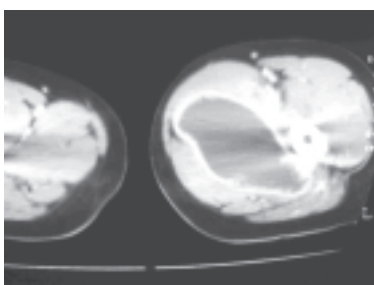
Enhanced axial CT scan taken at the level of the upper thighs.
